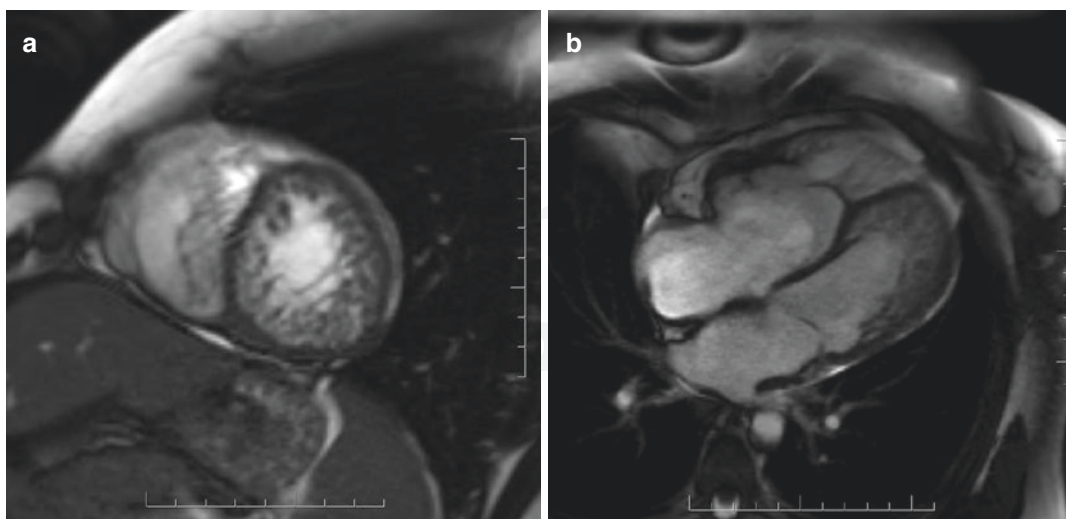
Cardiac magnetic resonance imaging of left ventricular noncompaction in a patient with Ebstein anomaly in short axis (a) and four chamber views (b)
